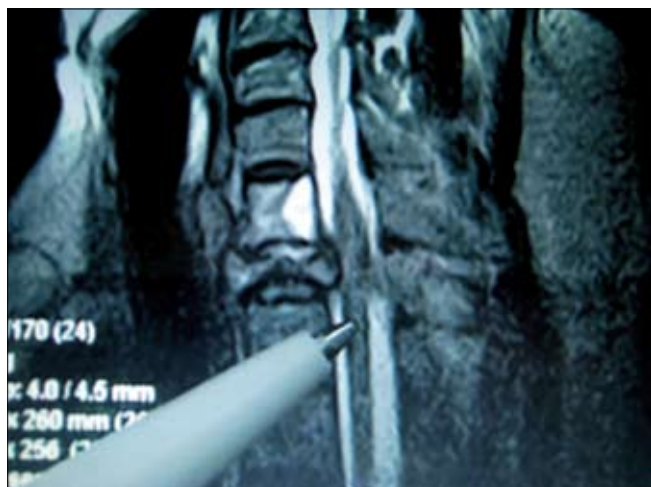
MRI (03.2004) – pathological fracture of the vertebral body of T2 with spinal cord compression and edema.
